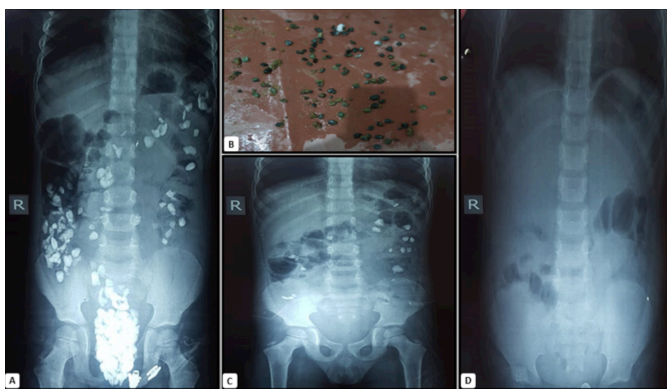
(A) Initial plain abdominal x-ray anteroposterior view showing numerous radiopaque densities in colon (lithobezoar) (B) Spontaneously passed lithobezoars (C) Follow-up plain abdominal x-rays anteroposterior view after a week showing significant improvement as compared to previous x-ray (D) Follow-up plain abdominal x-ray anteroposterior view after three weeks.
